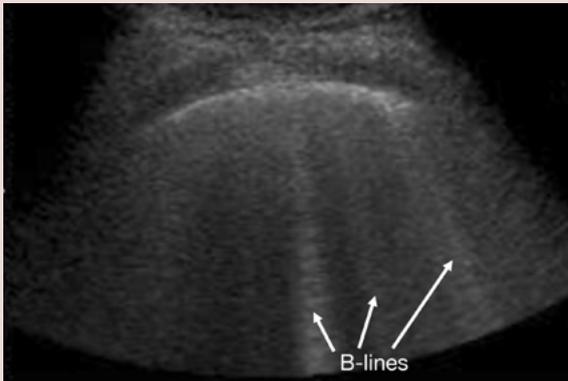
Lung ultrasound changes in a mild case of PCP: B-lines as a sign of the interstitial oedema.
